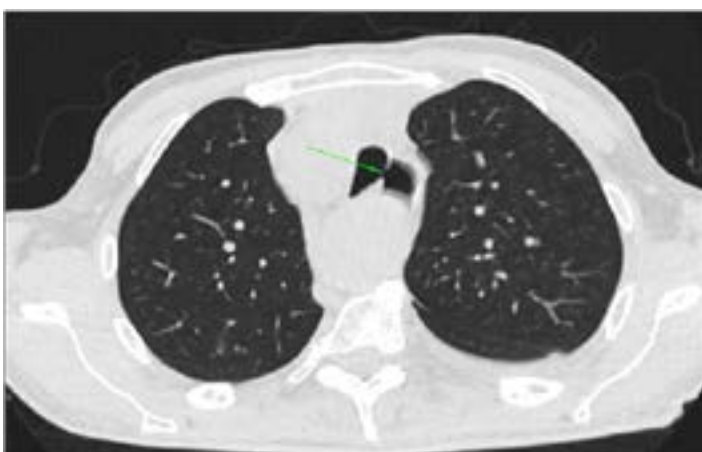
CT, Coronal view: fistular communication between left posterolateral portion of the distal trachea and the adjacent esophagus.
